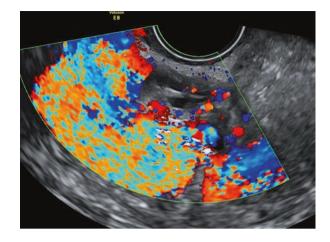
Colour Doppler image showing the colour-filled box as passage of saline from the fimbrial end of the tube suggesting the patency
